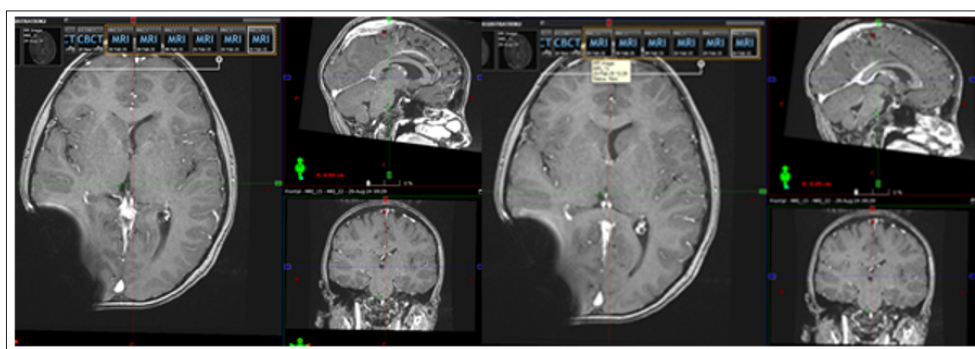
MRI from February 2025, 3 Months after the Completion of Local IMRT- Supratentorially and Infratentorially without Focal Changes. Ventricular System with Reduced Volume of the Right Lateral Ventricle on the Background of a Shunt. Normal width of the Third and Fourth Ventricle without Signs of Hydrocephalus. The Remaining Brain Structures without Changes.
